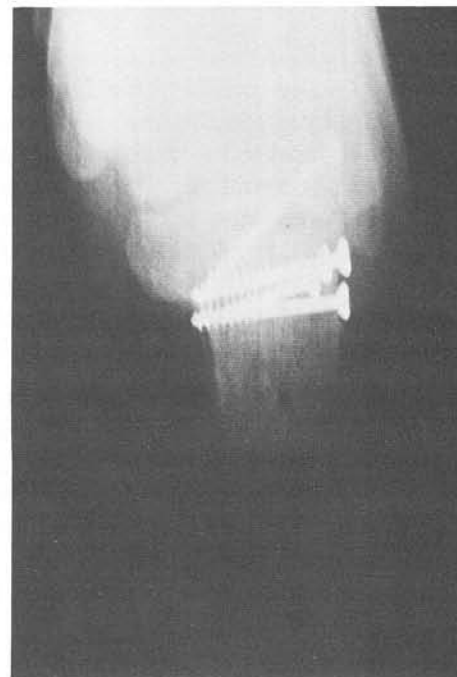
Intra-operative x-rays are used to confirm proper screw placement and adequate fracture reduction.
